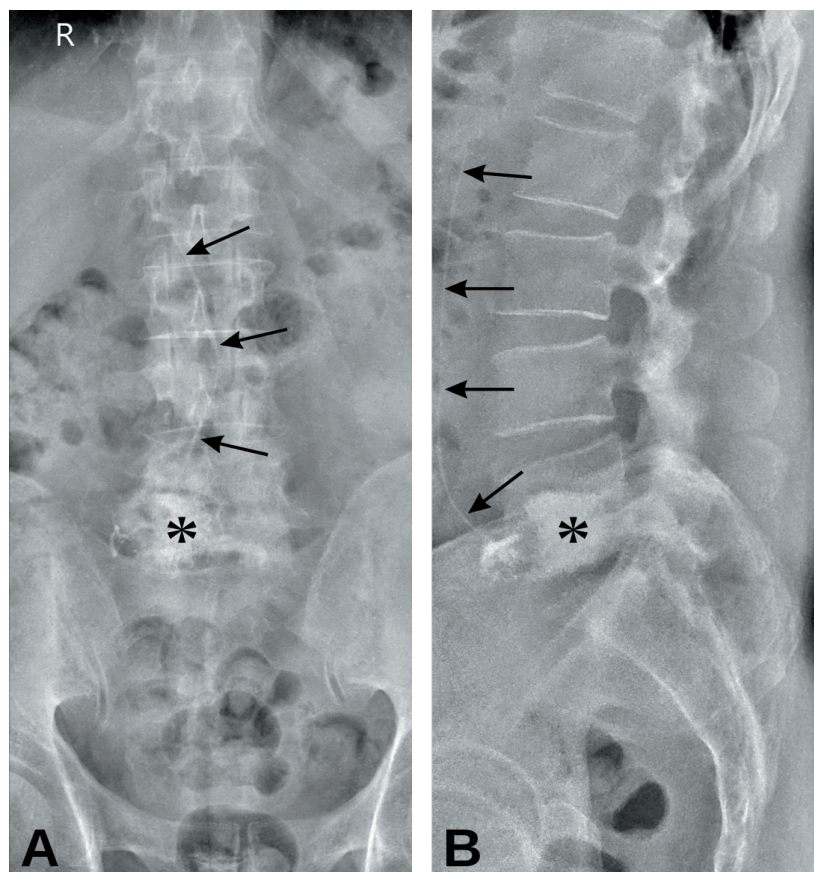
Anteroposterior (A) and lateral (B) lumbar spine radiographs. Hyperdense foci are observed in the right aspect of the L4 and L5 vertebral bodies, corresponding to bone cement following vertebroplasty (asterisks). A linear hyperdense tract extends anteriorly and superiorly from the cemented region, indicating cement leakage into the inferior vena cava (arrows).
